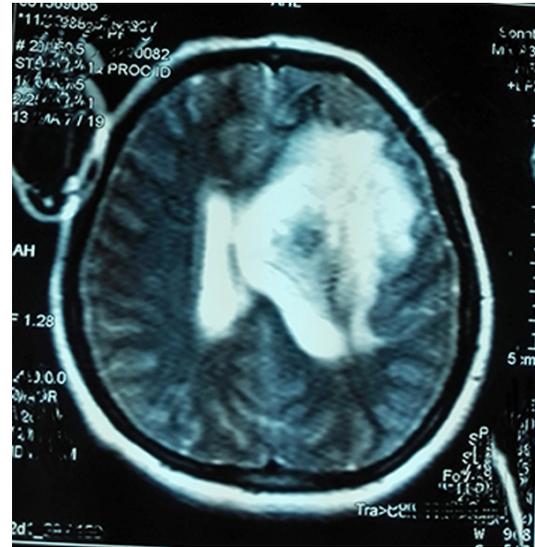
MR image prior to the second surgery.
